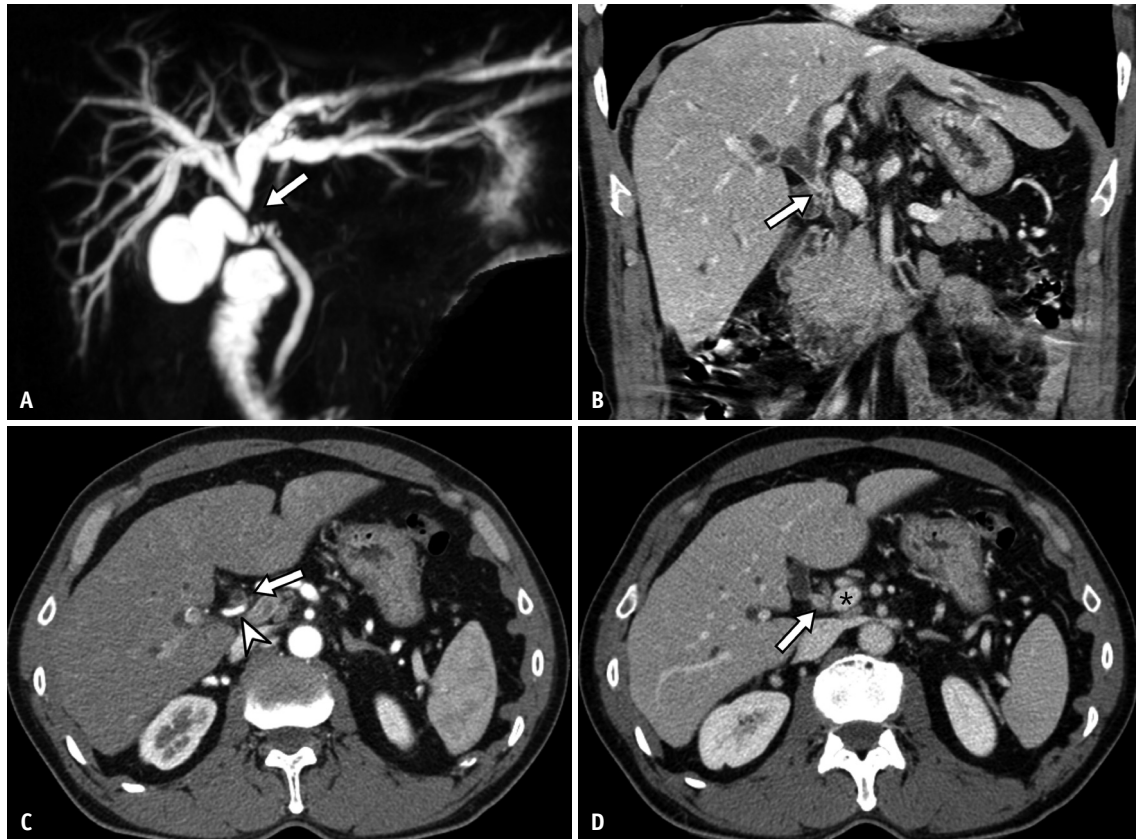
A 62-year-old male patient with surgically confirmed perihilar cholangiocarcinoma with pathologic staging of T2aN0. Three-dimensional MRCP (A) and CECT coronal portal venous phase image (B) demonstrate Bismuth type I CCA (arrows) and mild upstream bile duct dilatation. Axial arterial (C) and portal venous phase (D) images show that the tumor (arrows) does not encase the hepatic artery (C, arrowhead) and portal vein (D, asterisk). The tumor was assessed as “probably” or “definitely” resectable on both imaging modalities. However, after curative-intent hilar resection, tumor presence was observed in the right secondary confluence and left hepatic duct resection margin. MRCP = magnetic resonance cholangiopancreatography, CECT = contrast-enhanced computed tomography, CCA = cholangiocarcinoma
